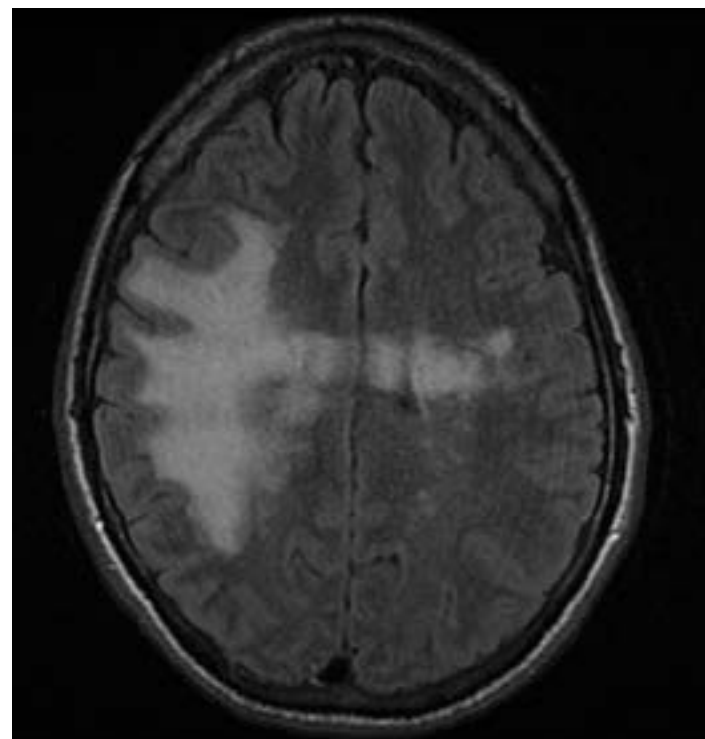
Repeat brain MRI one month later showing extension of the lesions associated with progressive multifocal leukoencephalopathy.
